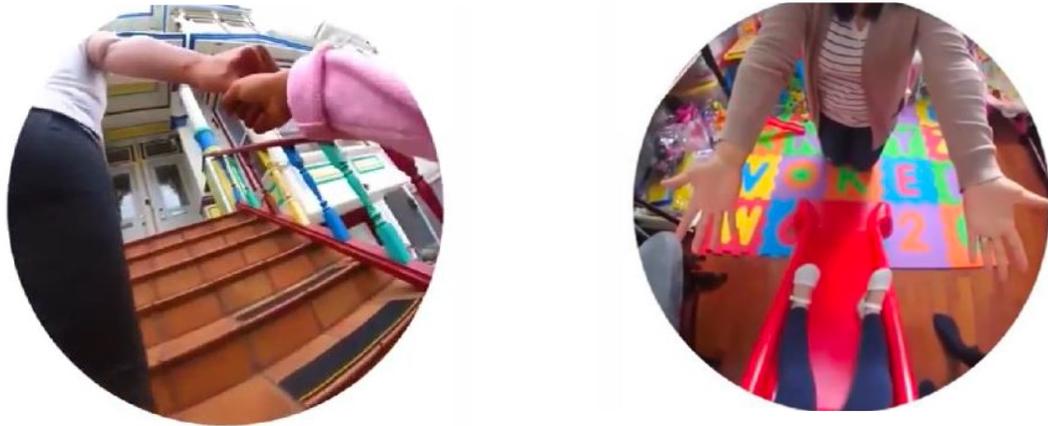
SCREENSHOTS FROM A COMMERCIAL CREATED WITH SNAPCHAT SPECTACLES (JARDINE, 2017; SMILEY, 2017)
